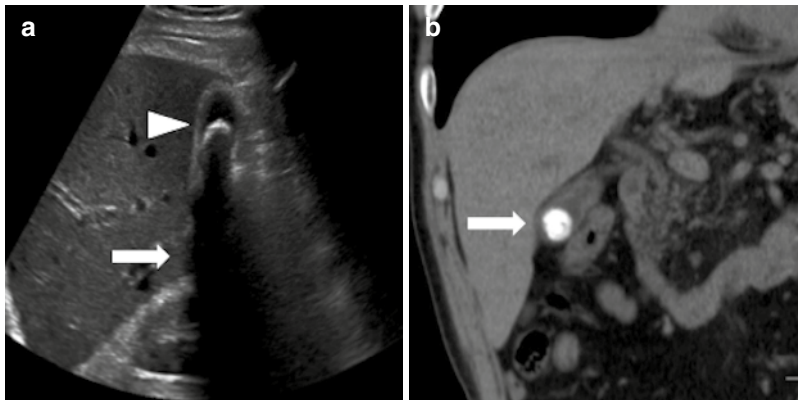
Abdominal ultrasound (US) and computed tomography (CT) of the same patient with a calcified gallstone. (a): Note the presence of the posterior shadowing (arrow) and the highly reflective echo from the anterior surface of the gallstone (arrowhead). (b): CT confirmed
